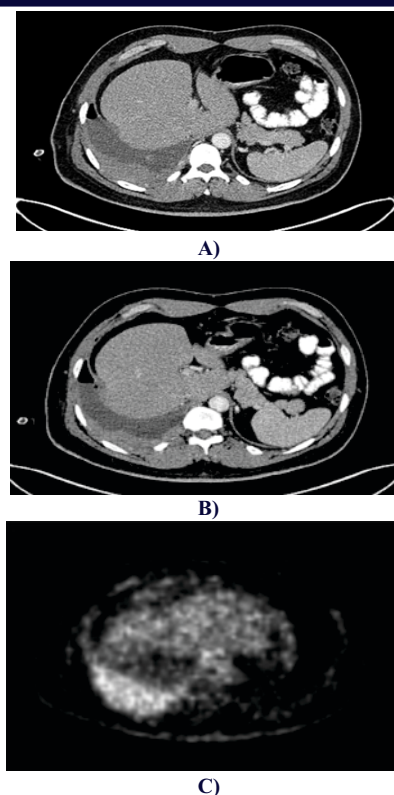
A & B) CT Chest with Contrast showing Right sided Pleural Effusion with Heterogenous Enhancement in Pleura suggesting Pleural mass. C) PET Image showing Enhanced Pleural mass in Right Pleural cavity.
